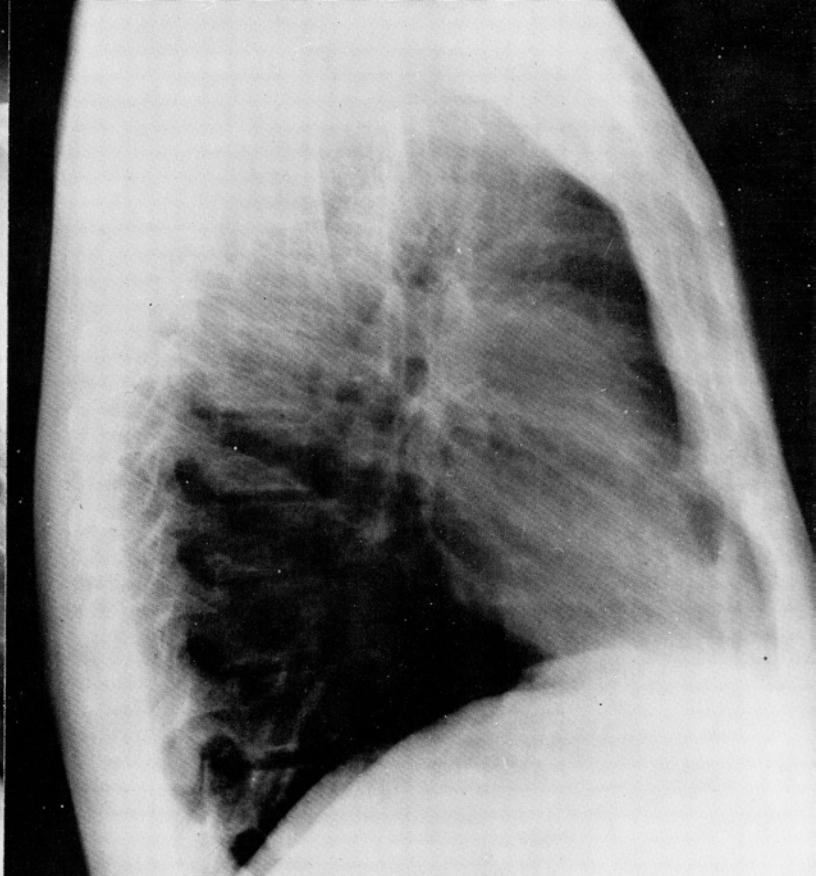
Lateral roentgenogram showing pre-hilar mass.
